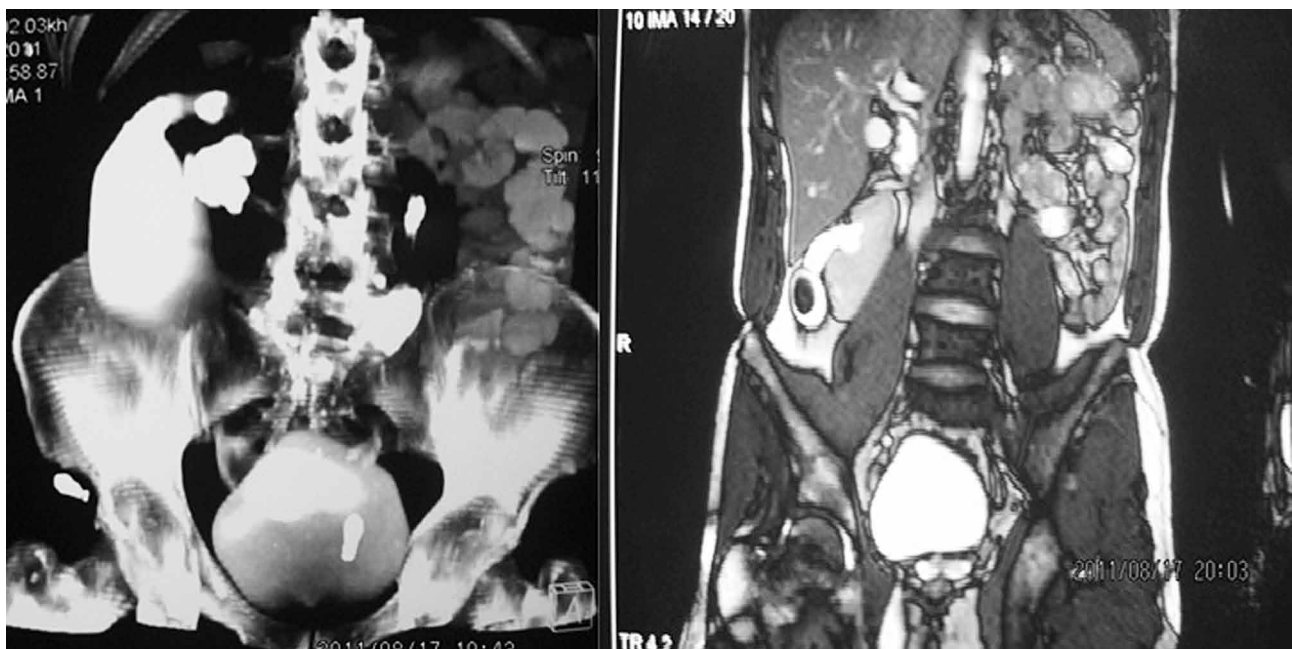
Coronal reconstruction of contrast-enhanced abdominal CT scan shows malrotated kidneys of both sides.
